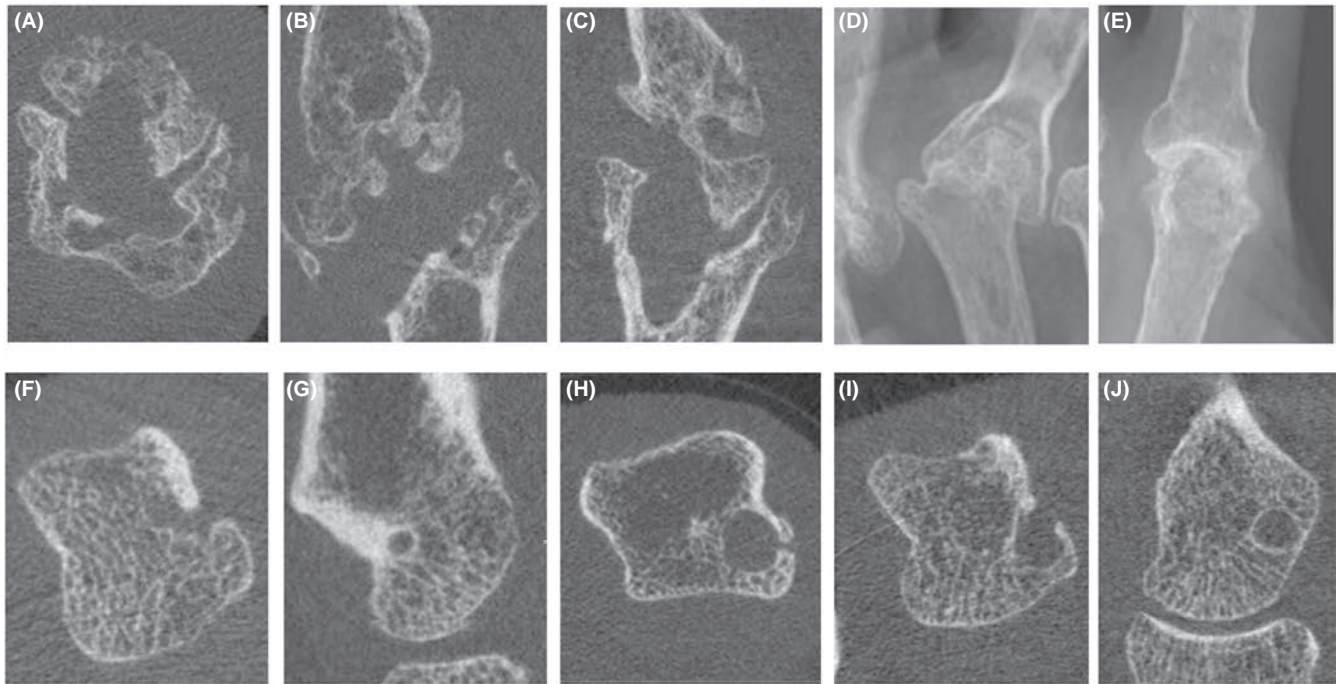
High-resolution peripheral quantitative computed tomography (HR-pQCT) images in axial (A), sagittal (B) and coronal (C) planes of a severely eroded metacarpophalangeal (MCP) joint. The proportion of damaged joint surface exceeds 50%. Cortical interruptions are few compared to the degree of bone loss. To the right, a conventional radiograph (D) of similar degree of destruction, which was graded as nine (maximum) on the van der HSS scale. Far right, a radiograph (E) of a lesser damaged joint showing superimposition of the metacarpal and phalangeal bones, leading to reduced visibility of erosions. Panels F–J show images of cysts in a healthy control subject (F and G), a patient with seronegative rheumatoid arthritis (RA) (H) and a patient with seropositive RA (I and J). The cysts demonstrate disproportional area of absence of trabecular structure at the site of a small cortical interruption (F and H) and a clear impression of a cyst wall (G and I)
